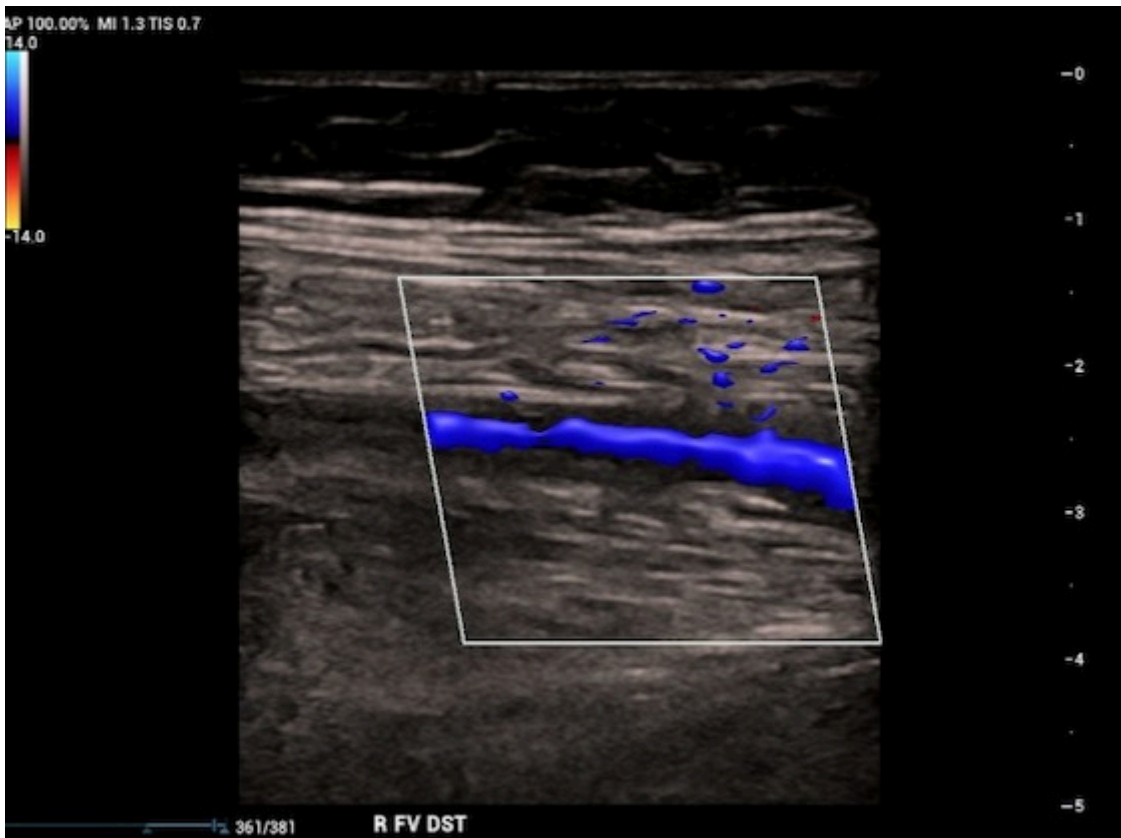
Long Axis color doppler image showing peripheral filling defect with central color flow in the femoral vein which is relatively smaller in diameter proximally compared to distally.
